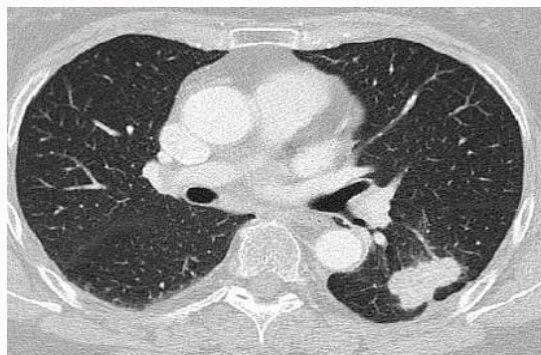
CT scan of the lung: tumoral mass of the lower lobe of the left lung.
